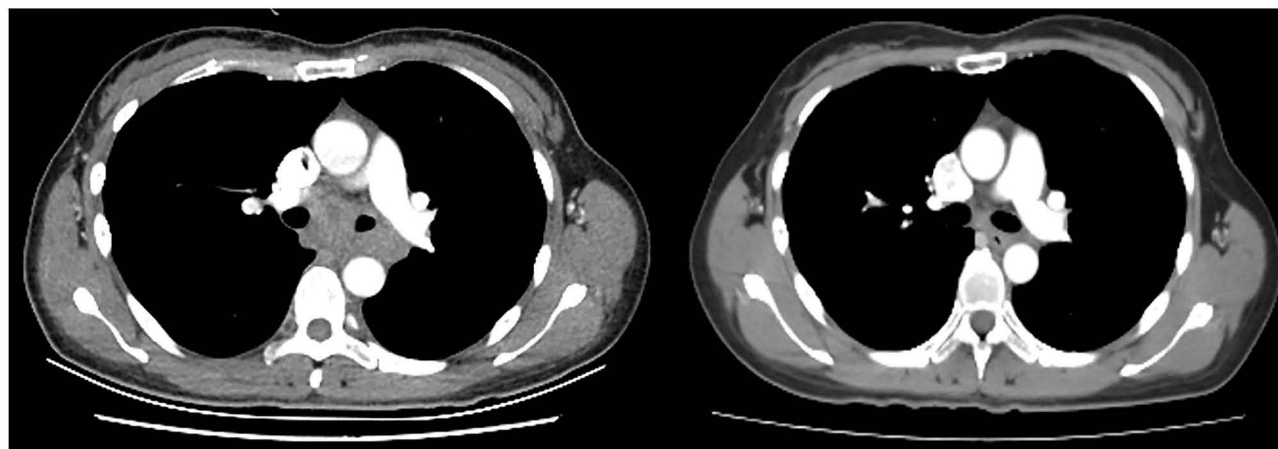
CT scan results of the changes for target lesions in the lung site of a female patient with ES-SCLC before and after the treatment of anlotinib plus tislelizumab.
